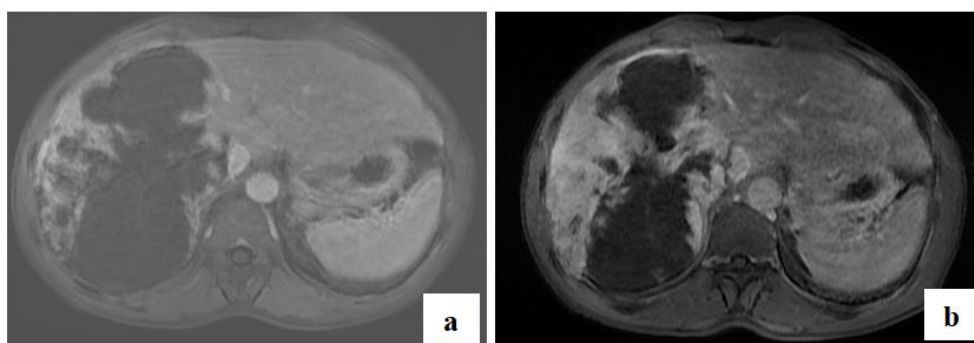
Axial-section T1 MRI after injection of Gadolinium at portal (a) and late (b) times, showing progressive enhancement in clots and centripetes
